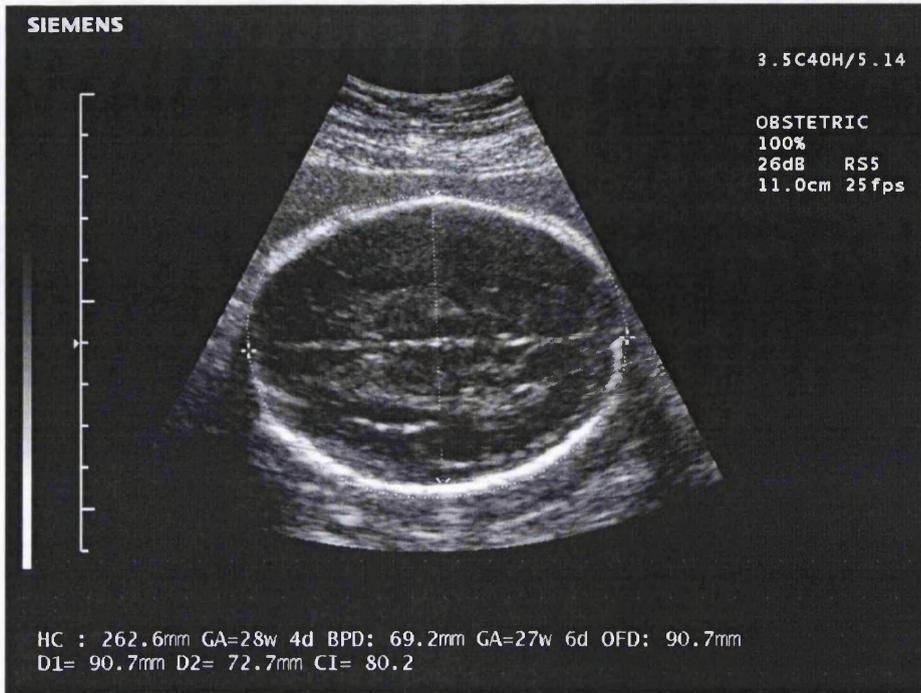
Ultrasound showing fetal head circumference, occipito-frontal diameter and bi-parietal diameter. Taken from (www.siemensultrasound.com)
